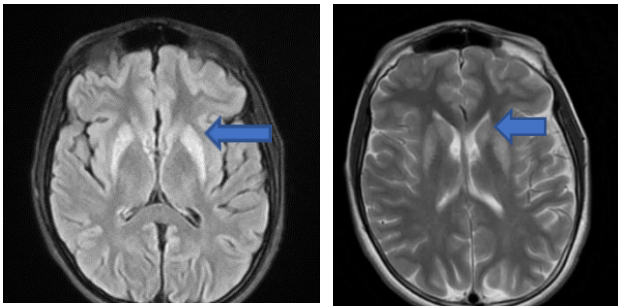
FLAIR and T2 weighted images
